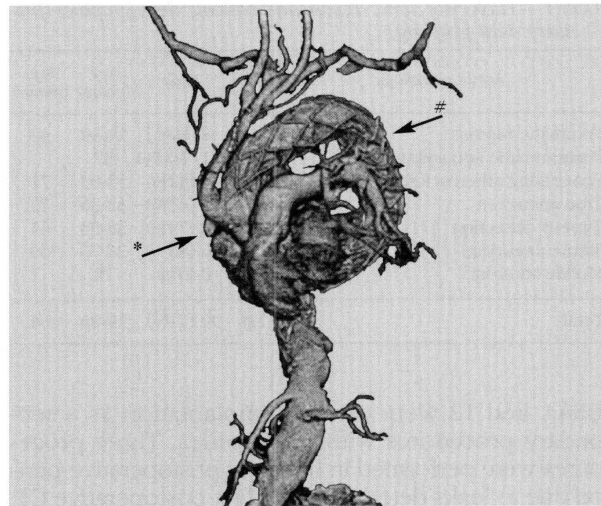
CT reconstruction of an E-vita thoracic® graft in a 74-year-old man. The stent-graft was implanted in the aortic arch and the proximal descending thoracic aorta as a proximal extension of a two segment Talent graft implanted 4 years before (#: overlap). The E-vita was implanted in antegrade manner with simultaneous total arch debranching and reconstruction with a Y-graft from the ascending aorta (*: stump of the auxiliary access graft for the stent-graft deployment).
